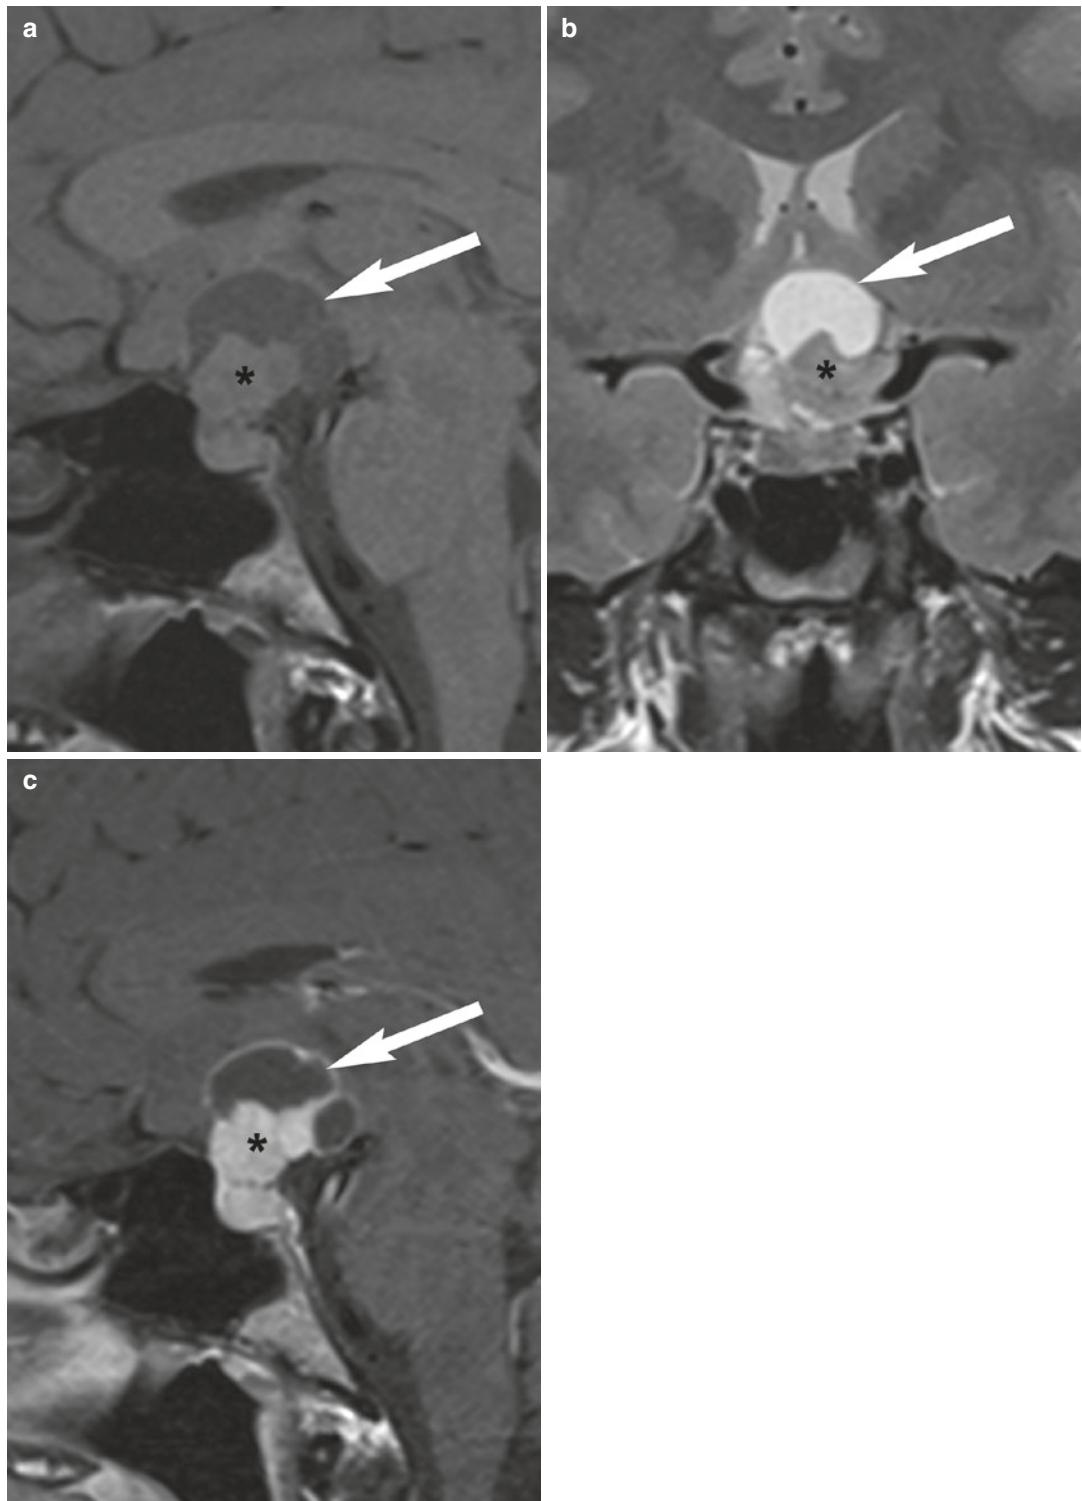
Craniopharyngioma, squamous-papillary. A 25-year-old male with headache and diplopia. Sagittal unenhanced T1-weighted (a), coronal unenhanced T2-weighted (b), and sagittal contrast-enhanced T1-weighted (c) images show a mixed solid and cystic
